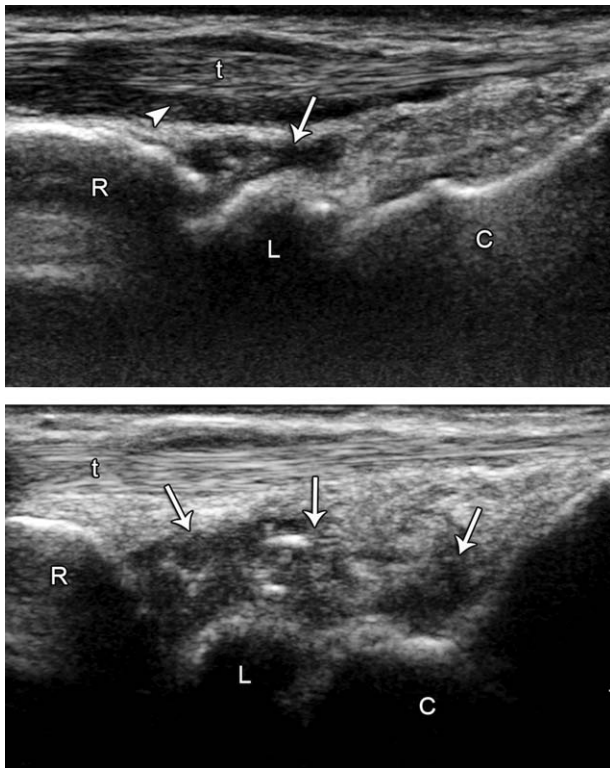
Joint recess and extensor tendon abnormalities are shown. (Top) Baseline sagittal ultrasound image over the dorsal wrist demonstrates hypoechoic fluid distending the (arrow) dorsal recess of the radiocarpal joint and (arrowhead) surrounding the extensor tendon. (Bottom) A 3-month sagittal ultrasound image over the dorsal wrist demonstrates heterogeneous hypoechoic fluid and synovitis distending the (arrows) dorsal recesses of the radiocarpal and midcarpal joints. R indicates radius; t, extensor tendon; L, lunate; C, capitate. The right side of the image is distal.
